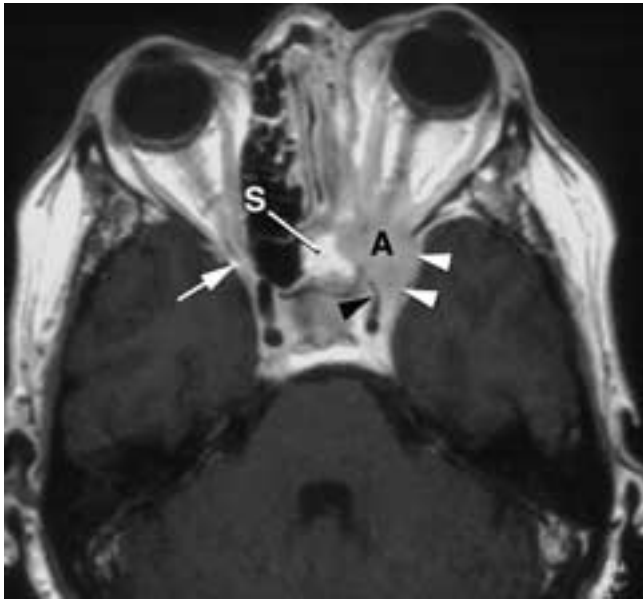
Aspergillus* of the sphenoid sinus extending into the orbital apex and cavernous sinus. Axial postcontrast T1-weighted image shows the *Aspergillus* (A) with moderate enhancement. The lesion was intermediate to slightly dark on T2-weighted images. There is expansion of the anterior cavernous sinus (white arrowheads), with narrowing of the carotid artery (black arrowhead). There are retained secretions in the more medial sphenoid sinus (S). Note how the bright fat protruding through the superior orbital fissure is obliterated on the left side. Compare this to the normal fat on the right side (white arrow).
